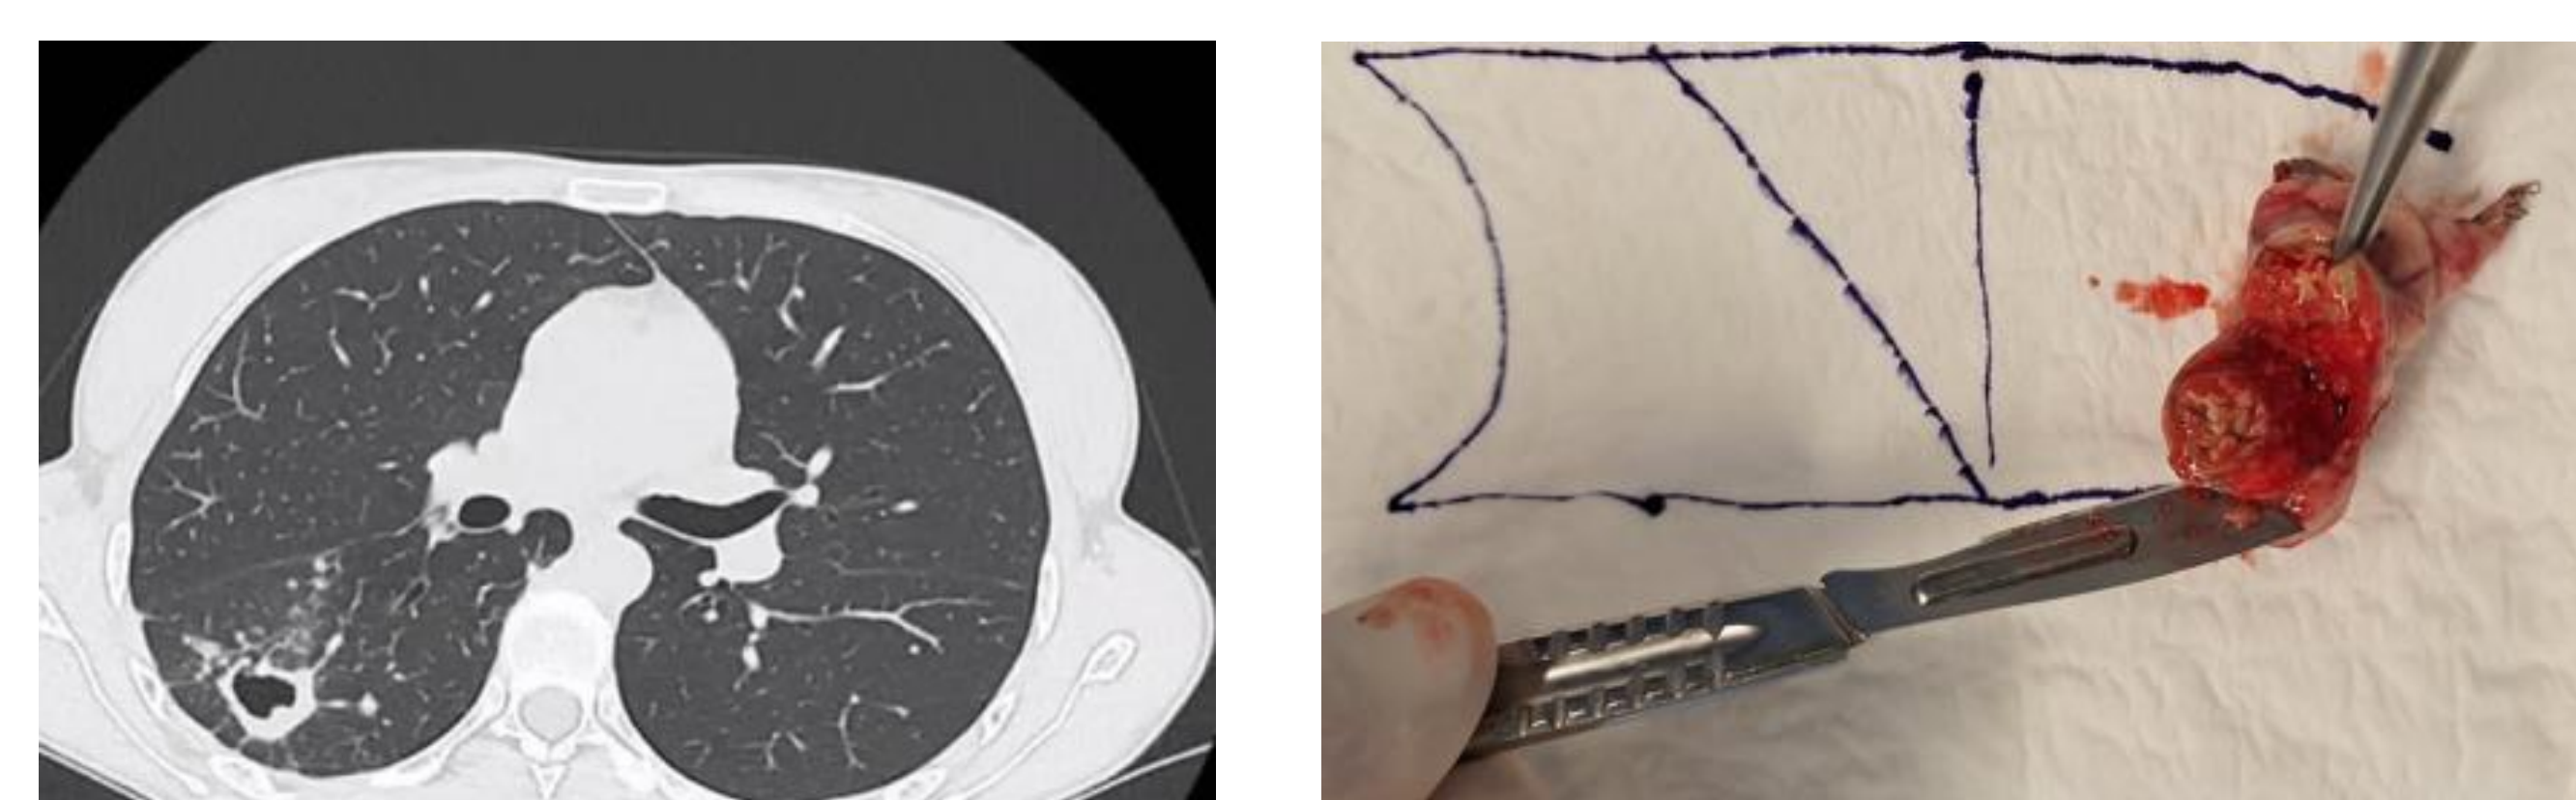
(left): Chest CT scan at 2 months showing disease progression with the appearance of new nodules and cavitations, as well as an increase in size of the pre-existing lesions.
